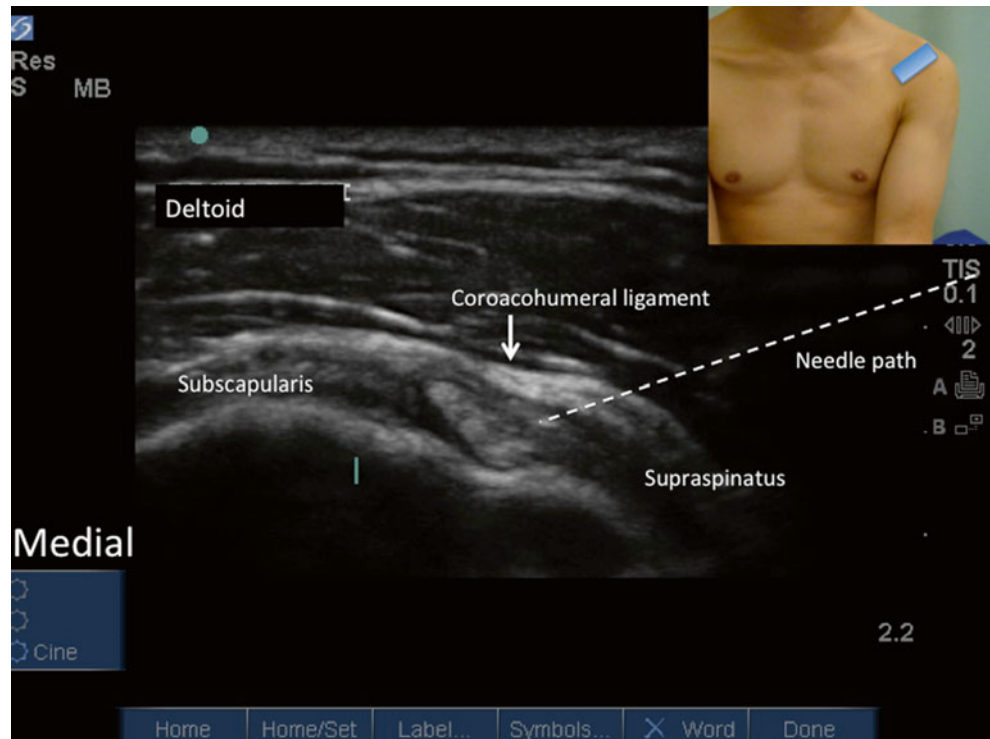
Sonogram showing the needle path for the injection of rotator cuff interval (Reproduced with permission from Philip Peng Educational Series)
